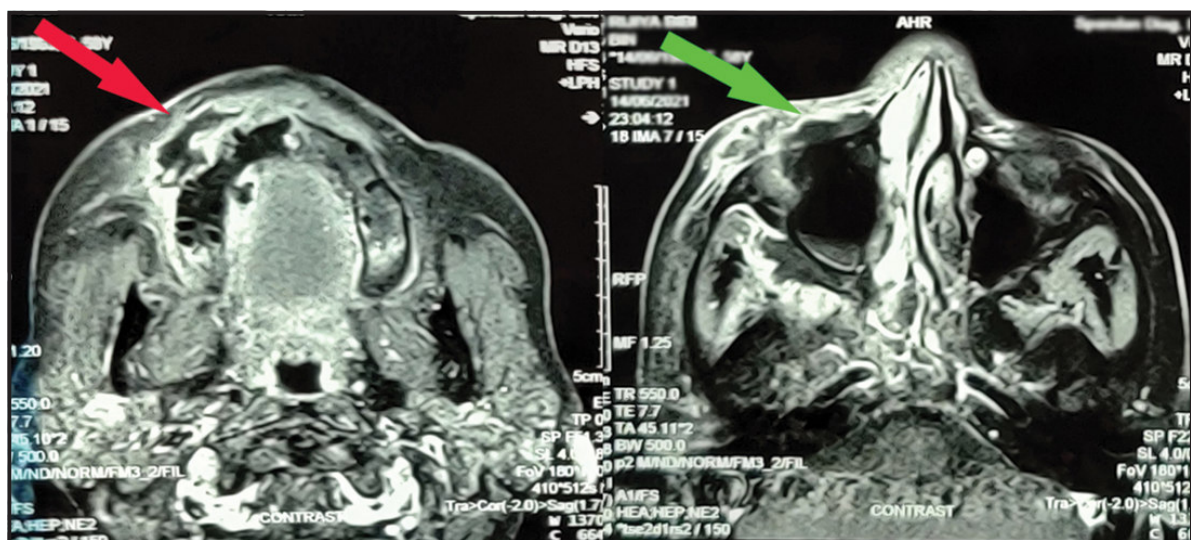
Axial cut of contrast enhanced T1 weighted MRI showing gum necrosis on the right side with abscess formation (red arrow). Green arrow shows necrosed areas of the maxilla, spreading to the pterygopalatine fossa on the right side.
